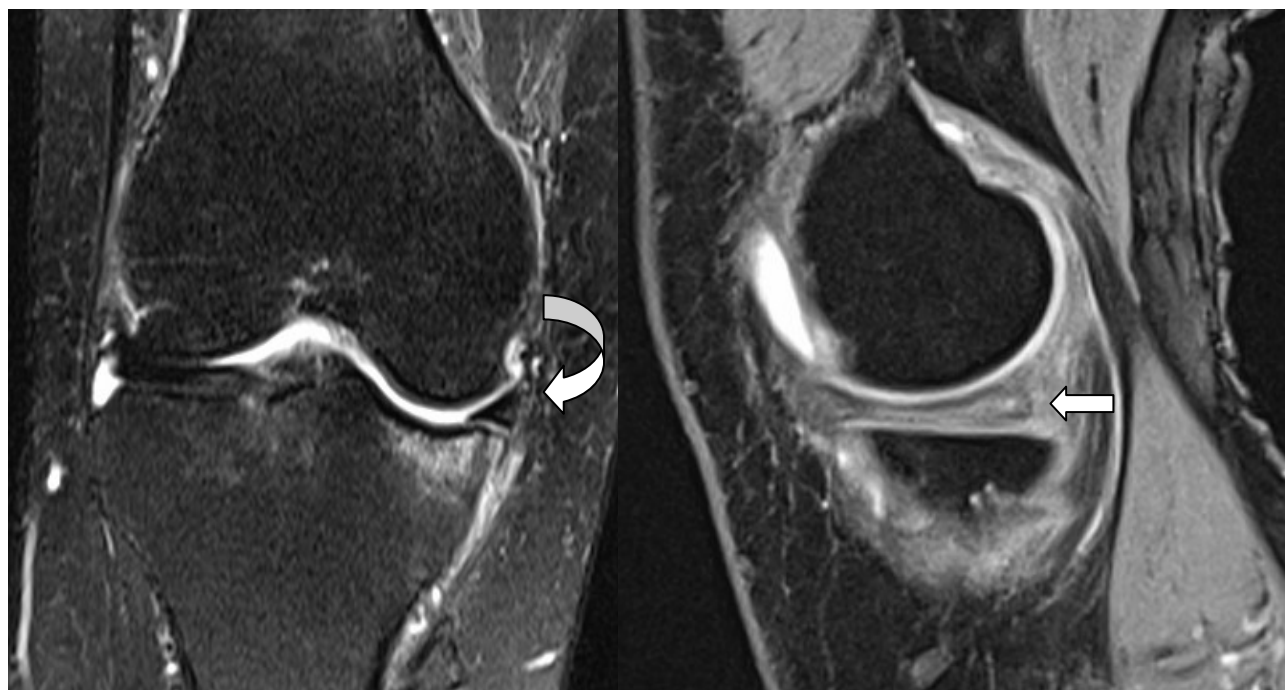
Right knee MRI images of a 58 year old female patient. T2 spin echo coronal fat saturated image of right knee showing full thickness cartilage defect in the medial femoro-tibial compartment (curved arrow) with associated bone marrow edema; the sagittal image showing diffuse hyperintense signals in the posterior root of medial meniscus with extension into inferior articular surface.
